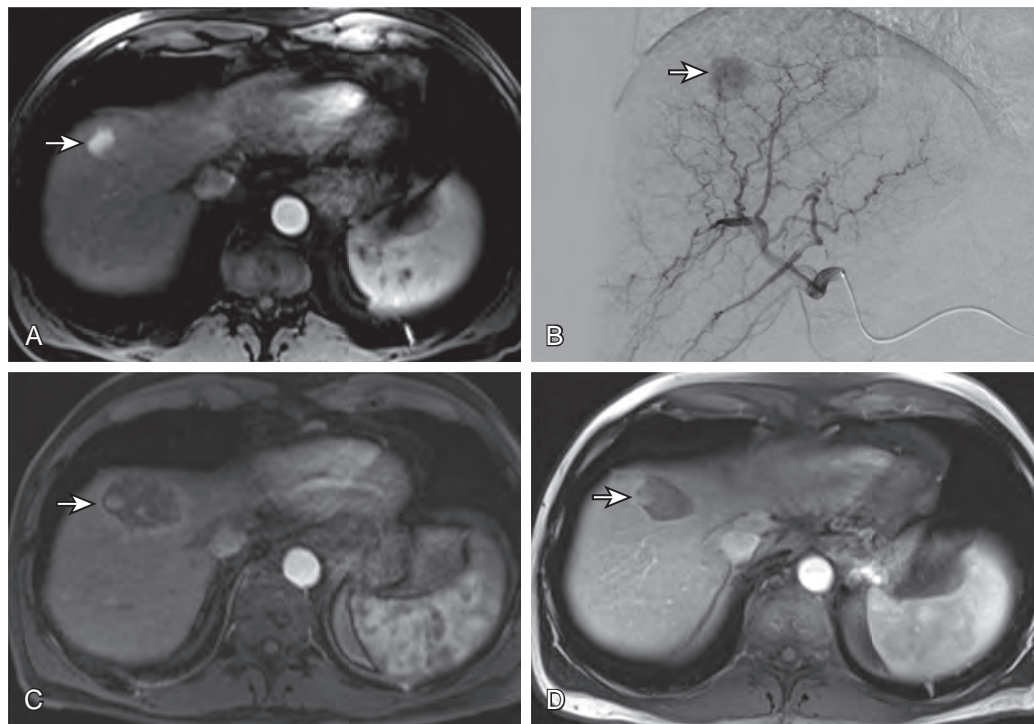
Effect of yttrium treatment on hepatocellular carcinoma. A. T1-weighted postcontrast MR image reveals a small enhancing hepatocellular carcinoma (arrow). B. Radioembolization shows a tumor blush (arrow). C. Image after radioembolization reveals the lesion to be larger with minimal enhancement (arrow). Full effect of radioembolization may take longer than in other liver-directed therapies. D. Follow-up MRI demonstrates complete nonenhancement compatible with tumor necrosis (arrow).
